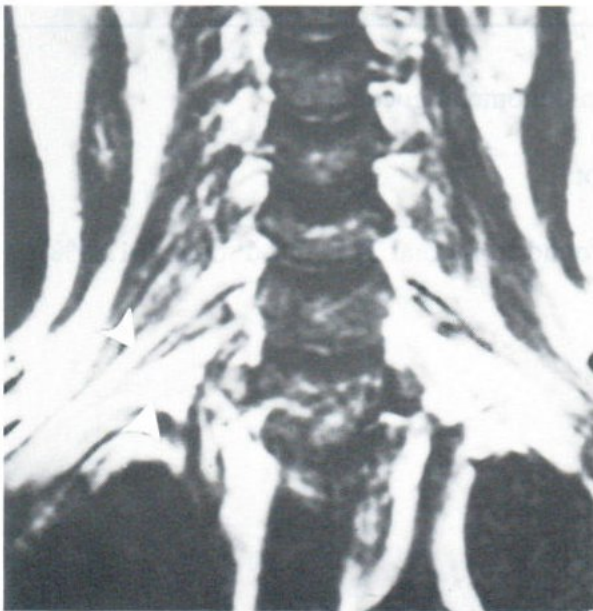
This patient clinically presented with total loss of motor and sensory function of Rt brachial plexus and he also had Rt axillary a. injury. MRI shows normal nerves. (two arrowheads), but neurodeficit caused by extrinsic compression from the hematoma. (Hematoma not demonstrable in this figure.)
